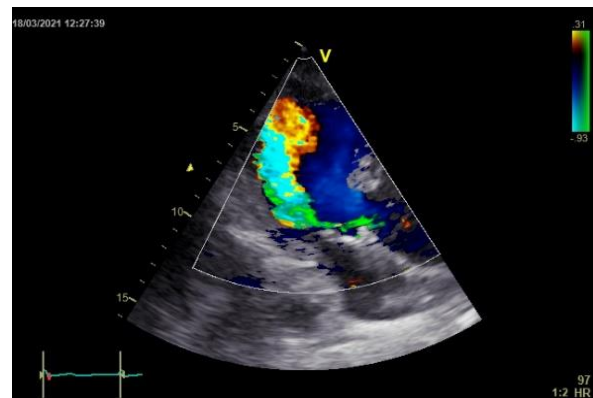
Colour Doppler showing significant AR
